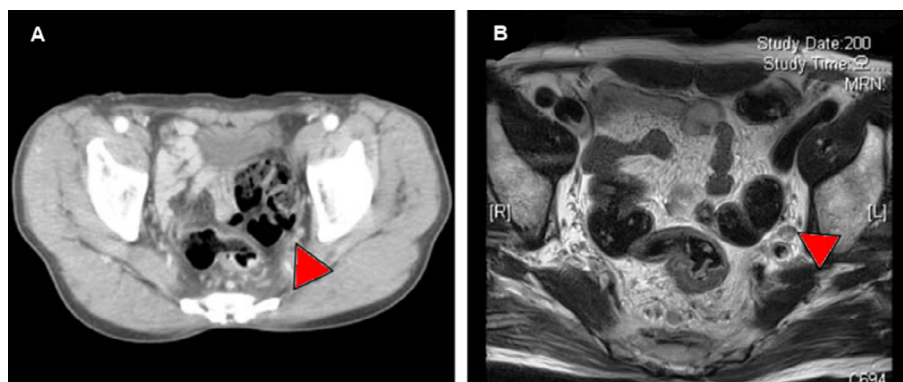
CT (A) and MRI (B) pelvis showing lateral nodal recurrence (arrow) following ISR.
